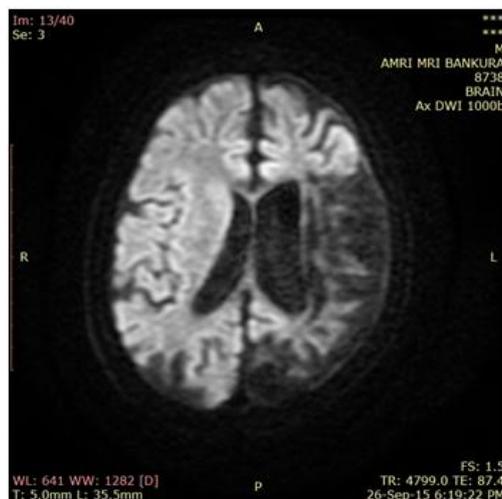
Axial DWI taken at TR 4799ms, TE 87.4ms and 250 kHz shows chronic left Para ventricular white matter infarct^[1,3,4]
